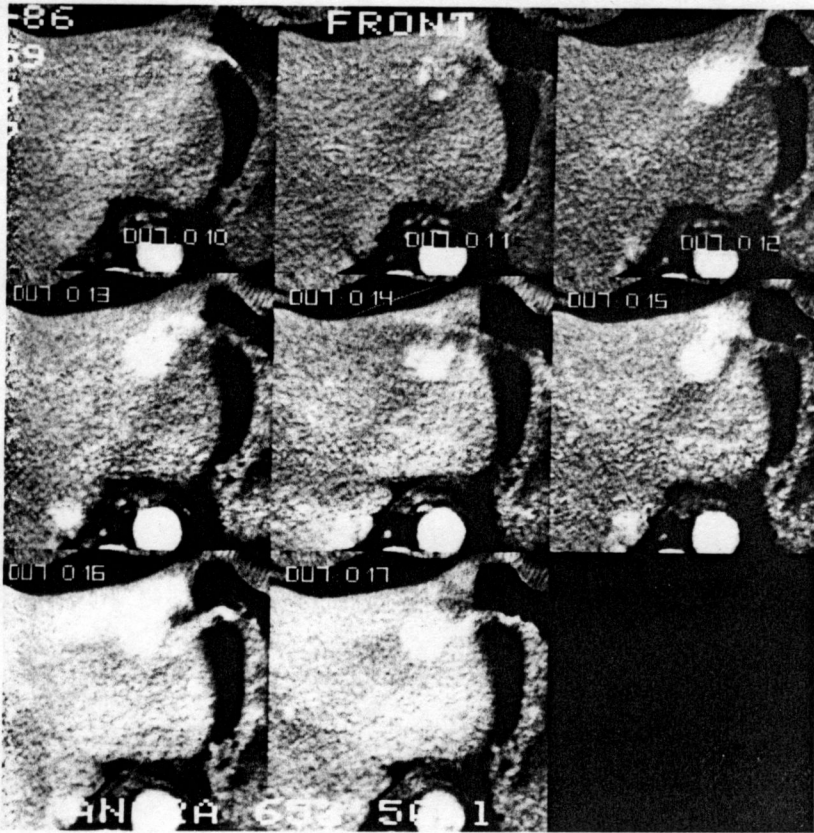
Dynamic CT scans of small hemangioma in the left hepatic lobe. Dense accumulation of contrast material progressively spreads throughout lesion in eight sequential scans acquired during a single breath-holding.
